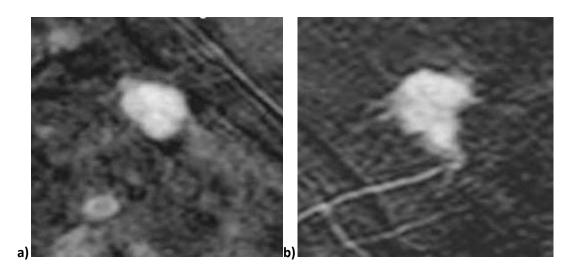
[98]: MRI of breast fibroadenoma with well-circumscribed margins (a) and MRI of invasive breast carcinoma with spiculated margins (b)
